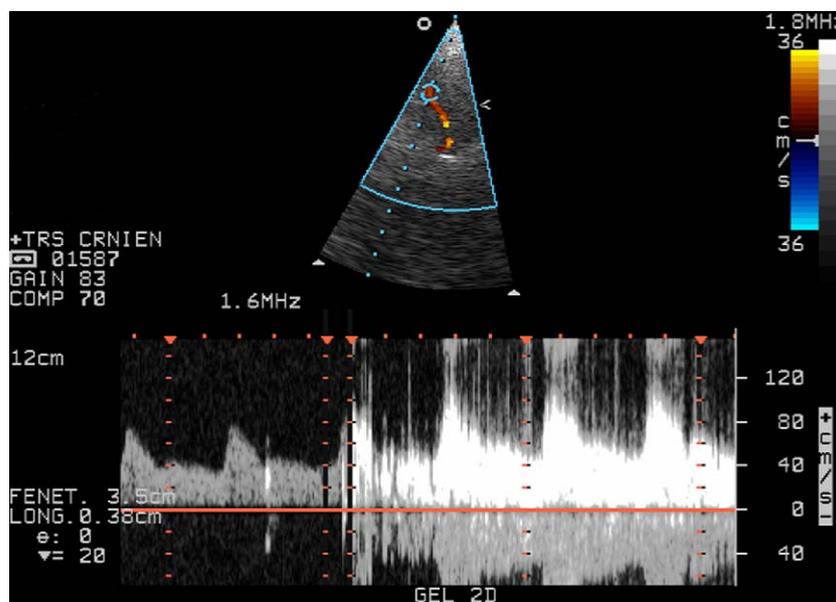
Large shunt with transcranial Doppler.
